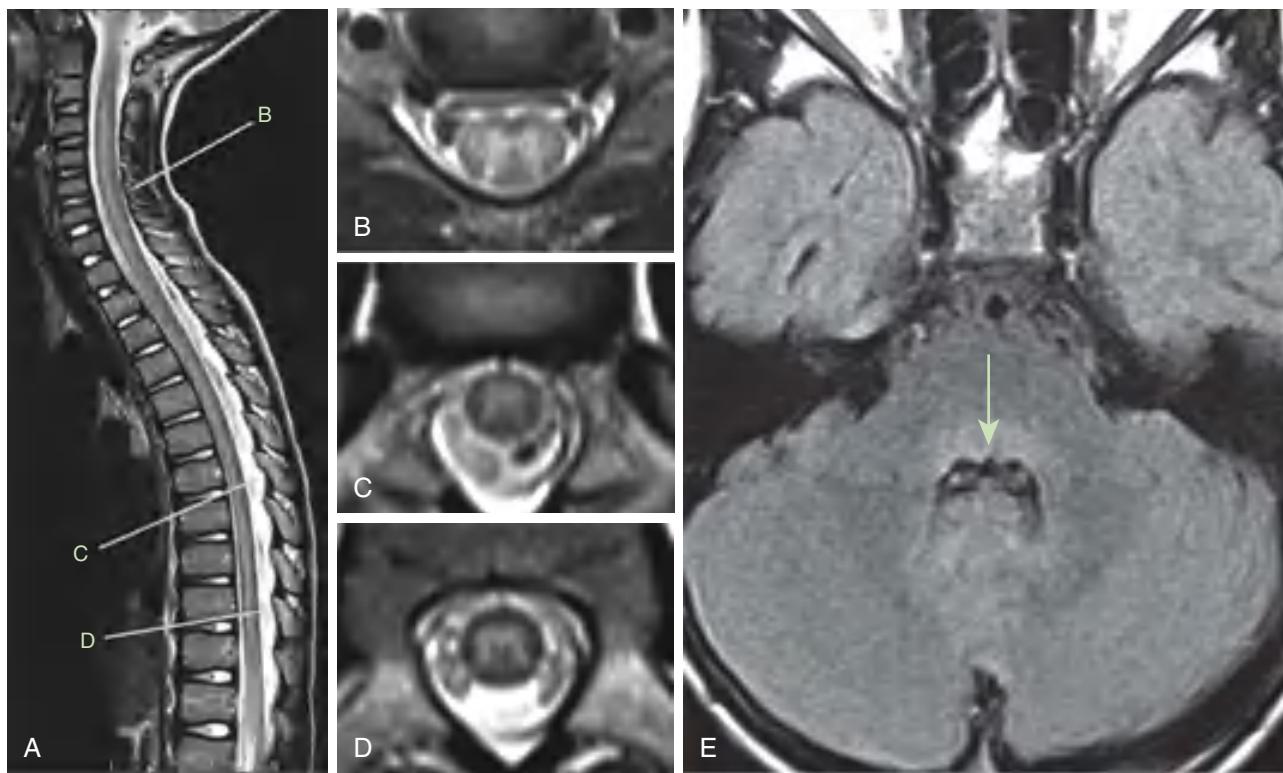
Typical MRI findings in the acute phase of AFM. Spinal MRIs are shown of an 8-yr-old child with AFM, acquired 24 hr after onset of neurologic symptoms. A, Sagittal T2-weighted image showing an ill-defined, longitudinally extensive central/anterior spinal cord lesion. B, Axial T2-weighted image from C5–C6 shows hyperintensity of the entire gray matter of the spinal cord, with associated edema and some surrounding white matter hyperintensity. C, Axial T2-weighted image from T7 shows asymmetric hyperintensity of the gray matter (right more than left). D, Axial T2-weighted image from T10 shows hyperintensity of the entire gray matter. E, Axial FLAIR image at the level of the middle cerebellar peduncle demonstrates hyperintensity of the dorsal pons (arrow). AFM, acute flaccid myelitis. (From Murphy OC, Messacar K, Benson L, et al. Acute flaccid myelitis: cause, diagnosis, and management. Lancet. 2021;397:334–344, Fig. 1, p. 338.)
